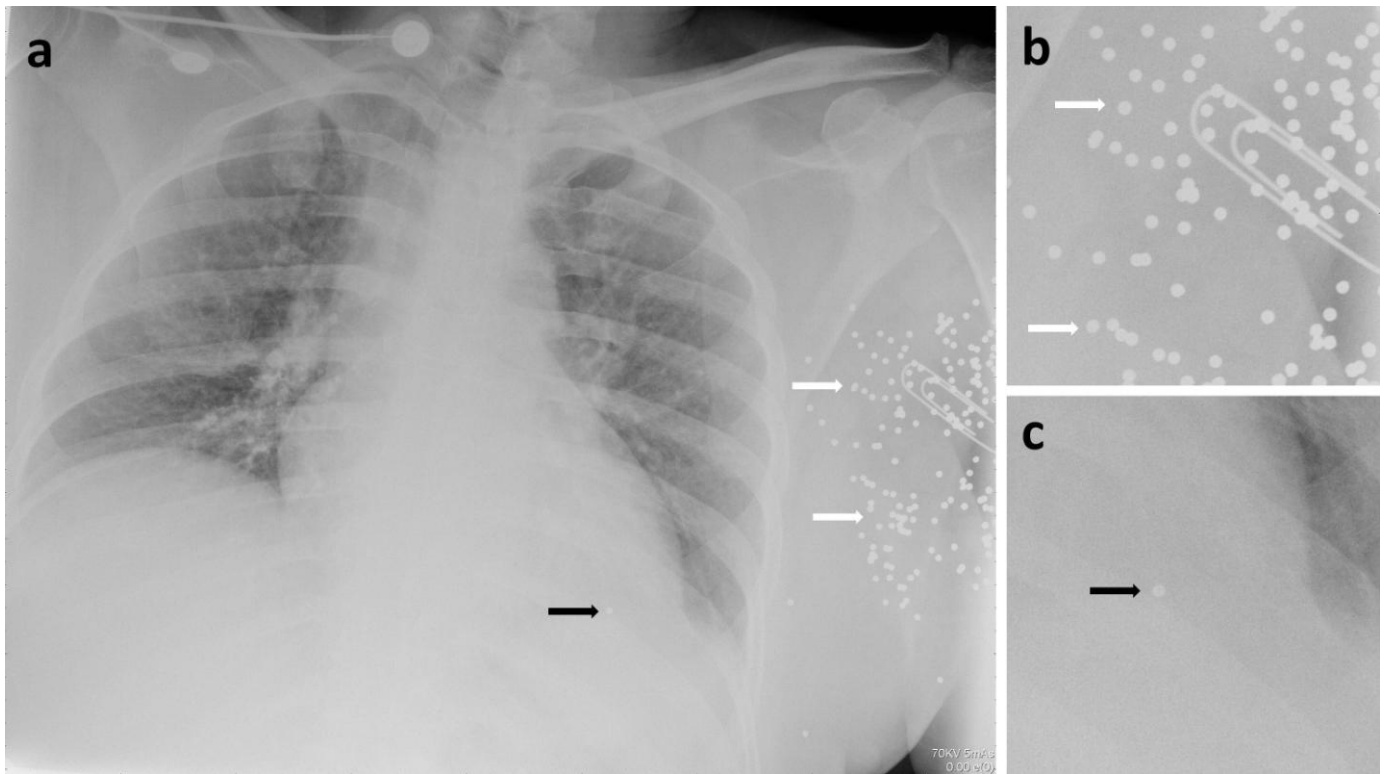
54-year-old female with bilateral shotgun pellet pulmonary emboli following a left upper extremity shotgun wound. Initial anteroposterior chest radiograph (a) and detail views of the left axillary region (b) and left heart (c) demonstrating numerous shotgun pellets projecting over the left axilla and arm (white arrows in a and b) and one projecting over the left heart (black arrows in a and c), but none projecting over the lungs. A paperclip marks the entry site wound. (Protocol: Anteroposterior portable chest radiograph, 70 kV, 5 mAs).
